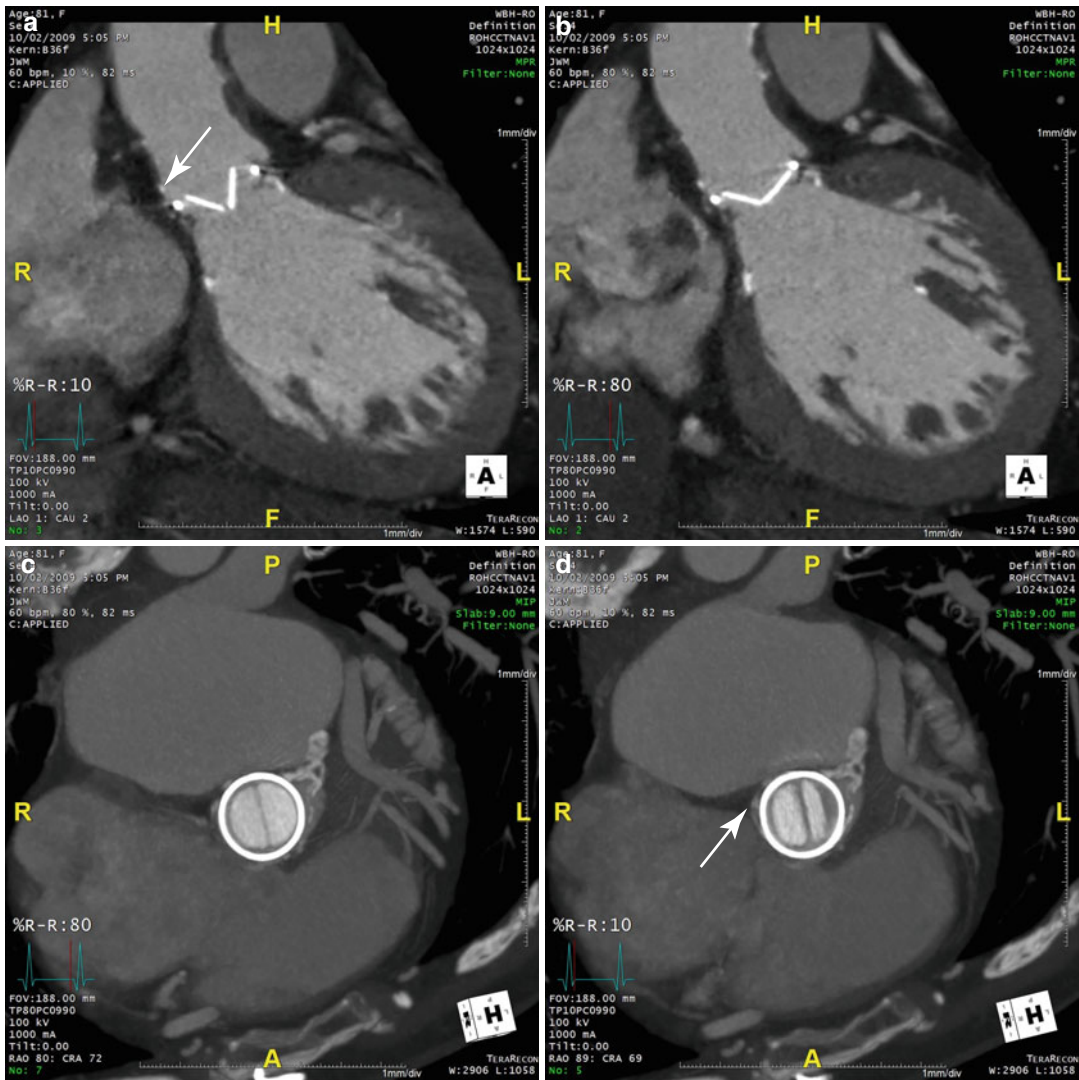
In systole (a and d) and diastole (b and c). Fixed leaflet is highlighted by the *arrow*. (a–d) Functional gated cardiac CT angiography demonstrating dynamic valve motion and the presence of one fixed leaflet
